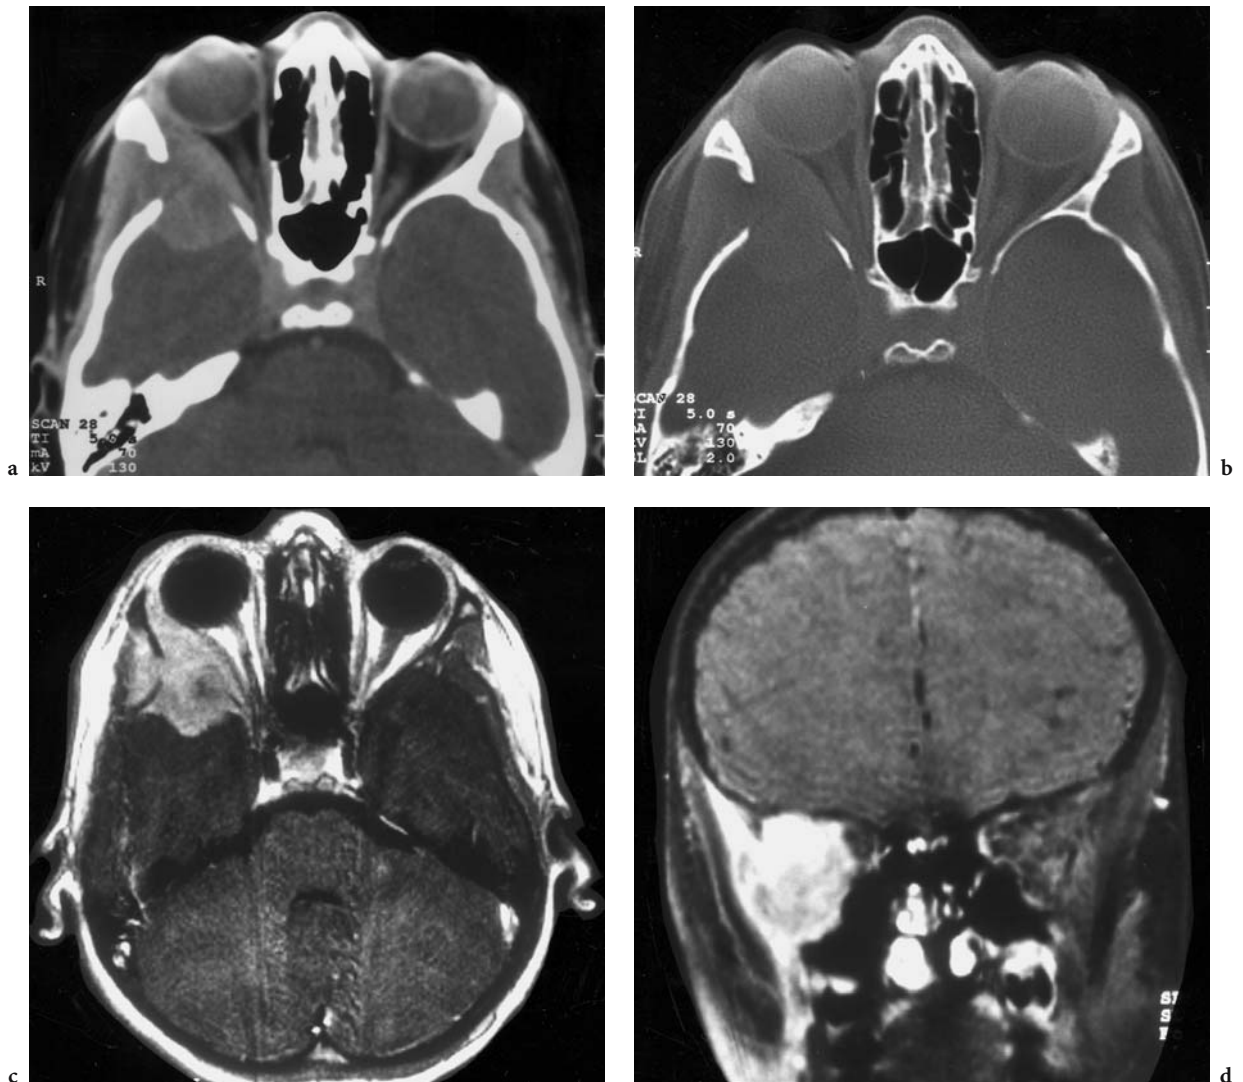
An 8-year-old boy with right orbital pain persisting for 2 months, followed by proptosis after 1 month; no neuro-ophthalmologic deficit. Diagnosis: Langerhans-cell histiocytosis. CT: a Axial contrast-enhanced view, demonstrating bony destruction of the large wing of the sphenoid bone, including parts of the zygomatic and temporal bone. A sharply defined, homogeneous lesion extending into the orbit is seen, with apparent dislocation of the lateral rectus muscle, and further extension to the posterior part of the lacrimal gland as well as subperiosteal in the direction of the optic canal. b Corresponding bone window. T1-weighted MRI: c Axial contrast-enhanced image, corresponding to a with distinct differentiation of the lateral rectus muscle from the tumor. Note superior identification of additional infiltration of the temporal fossa than on CT. d Coronal contrast-enhanced (FS) view, showing the craniocaudal dimension of the tumor with extension to the orbital roof. (MR images with permission of Drs Eberle, Krohn, Friedburg)
